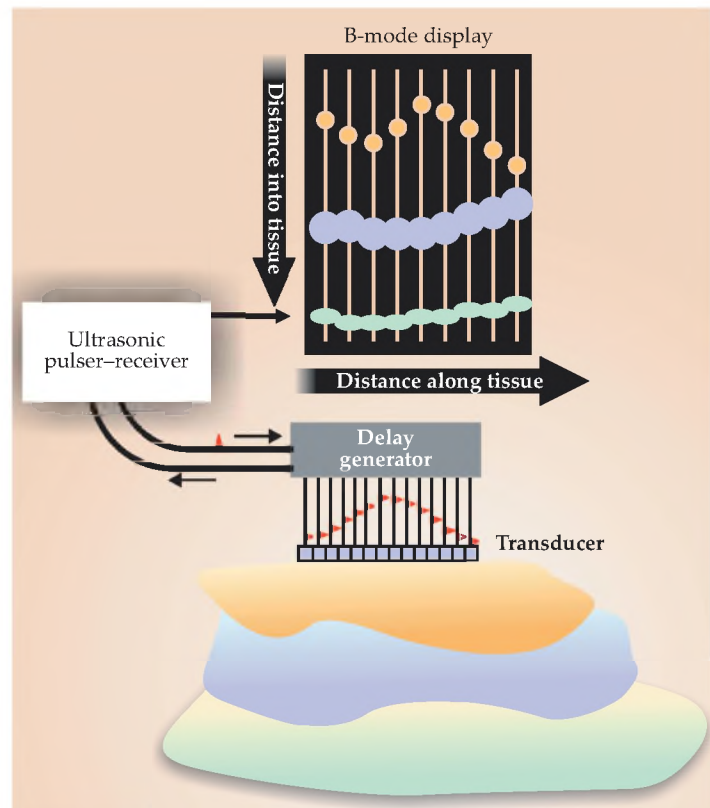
In a B-mode ultrasound image, a transducer scans along a tissue surface and the amplitudes of the reflected ultrasound pulses are encoded as brightness. The display plane is defined by the ultrasound beam and the scanning direction. (Courtesy of Pierre D. Mourad and Shahram Vaezy, University of Washington, Seattle.)
